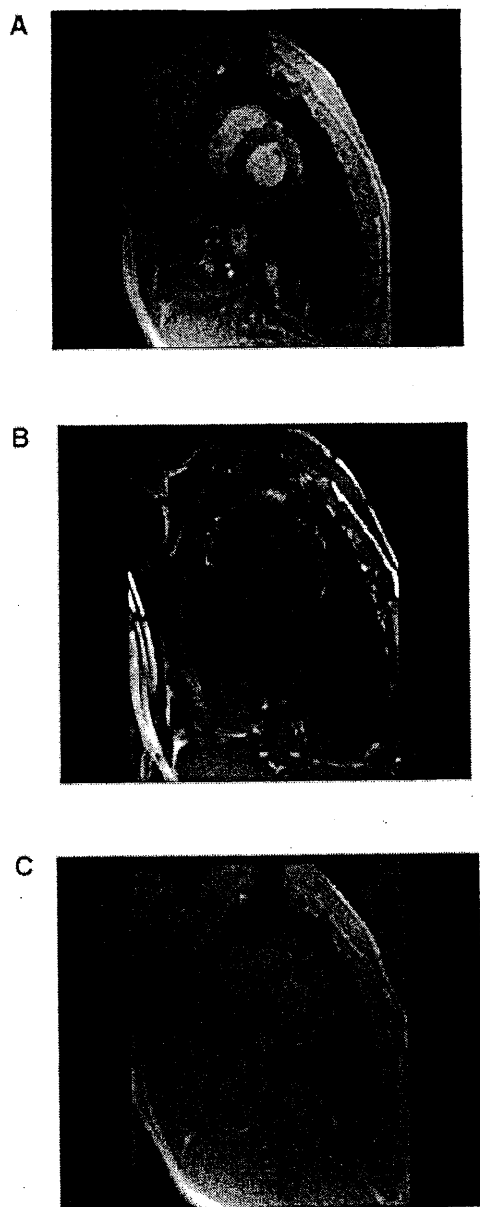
Representative MRI images of the DCD heart before (A), during (B) and after (C) circulatory arrest.
